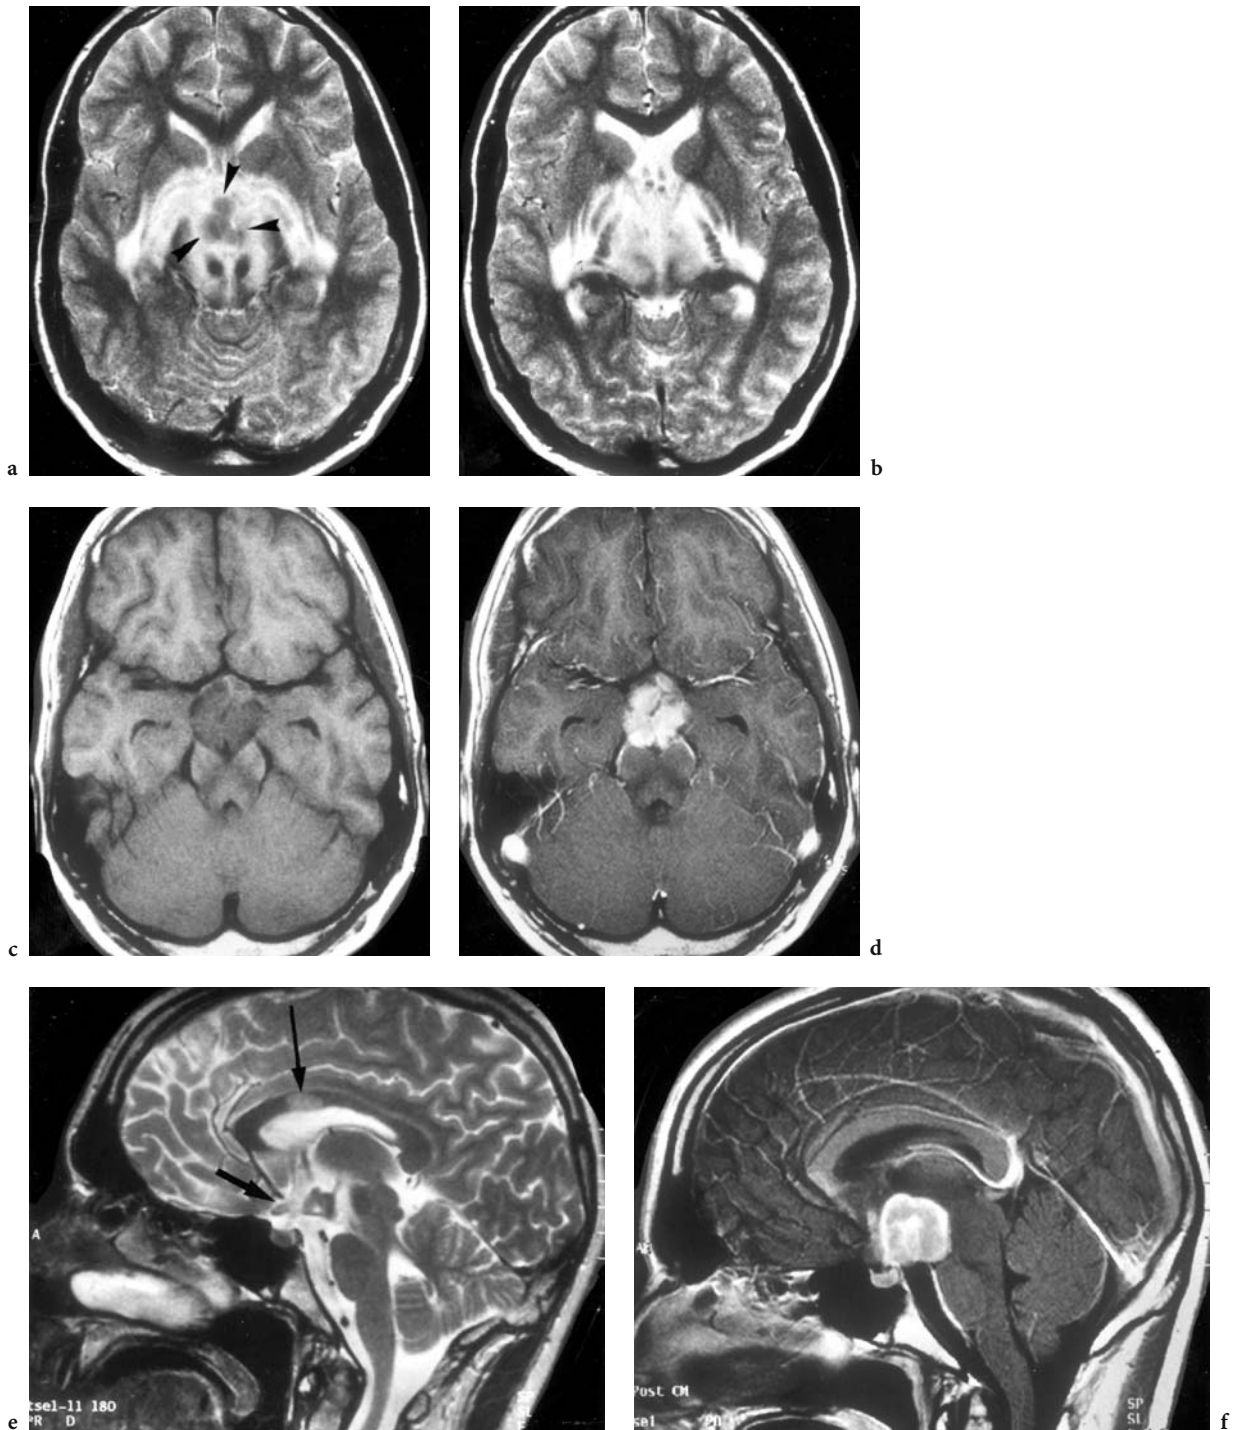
A 15 year old boy who presented with increasing weight, apathy, adynamia, and excessive memory defects, but no proven visual or additional hypothalamic disturbances (e.g., diabetes insipidus). Diagnosis: Langerhans cell granuloma. MRI: a Axial T2-weighted image at the level of the anterior commissure. In addition to an extensive edema along the anterior commissure and cerebral peduncle, an isointense, irregular, medially located mass is seen (*arrowheads*). b Axial T2-weighted view at the level of the interventricular foramen, demonstrating the widespread edema in both striate and thalami. c Axial T1-weighted native view at the level of the chiasm, which is seen compressed between the anterior cerebral arteries and the mass, extending through the entire interpeduncular cistern. d Corresponding contrast-enhanced view, demonstrating the extensive signal enhancement of the lesion. e Paramedian, sagittal, T2-weighted image, demonstrating the hypothalamic mass and slight swelling of the chiasm (*arrow*). Note another focus in the anterior part of the corpus callosum (*thin arrow*). f Midsagittal, T1-weighted, contrast-enhanced view, where the entire mass is apparent
